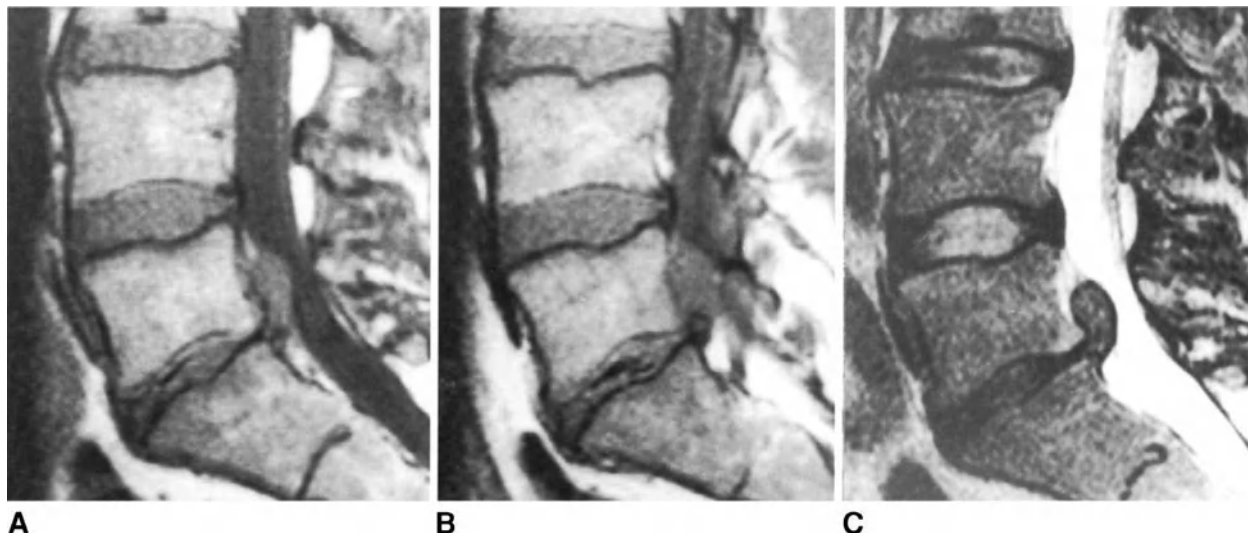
Retroligamentous extruded disc herniation, migrated proximally, at L5-S1 level. Spin-echo T1-weighted (A) and (B), and turbo spin-echo T2-weighted (C) sagittal images. The herniated disc fragment has migrated cranially as far as the proximal one third of L5, but it appears to be connected to the disc by a thin pedicle of tissue on the turbo T2-weighted image. This herniation may be classified as extruded or migrated. From the surgical viewpoint, it is preferable to classify it as migrated.
